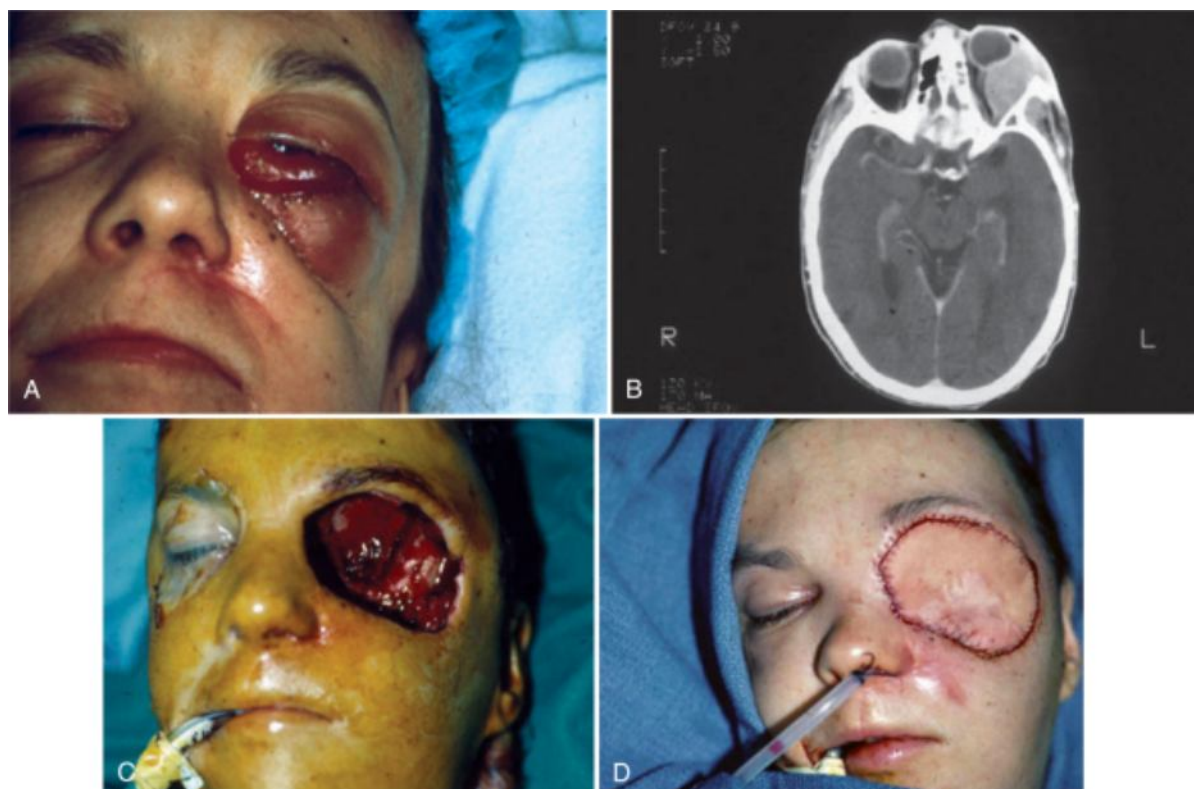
A, Patient with a sarcoma of the maxilla treated by maxillectomy. Recurrence in the orbit was treated with radiation therapy. The tumor recurred once again and destroyed the orbital contents. B, Computed tomography scan demonstrating invasion of the orbit and destruction of the bony orbital wall. C, Defect after orbital exenteration. D, Reconstruction with a rectus abdominis free tissue transfer.
